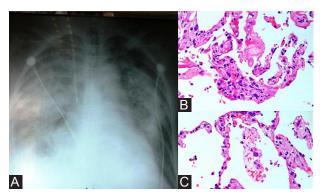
Chest X-ray at the time of respiratory distress and postmortem lung biopsies
